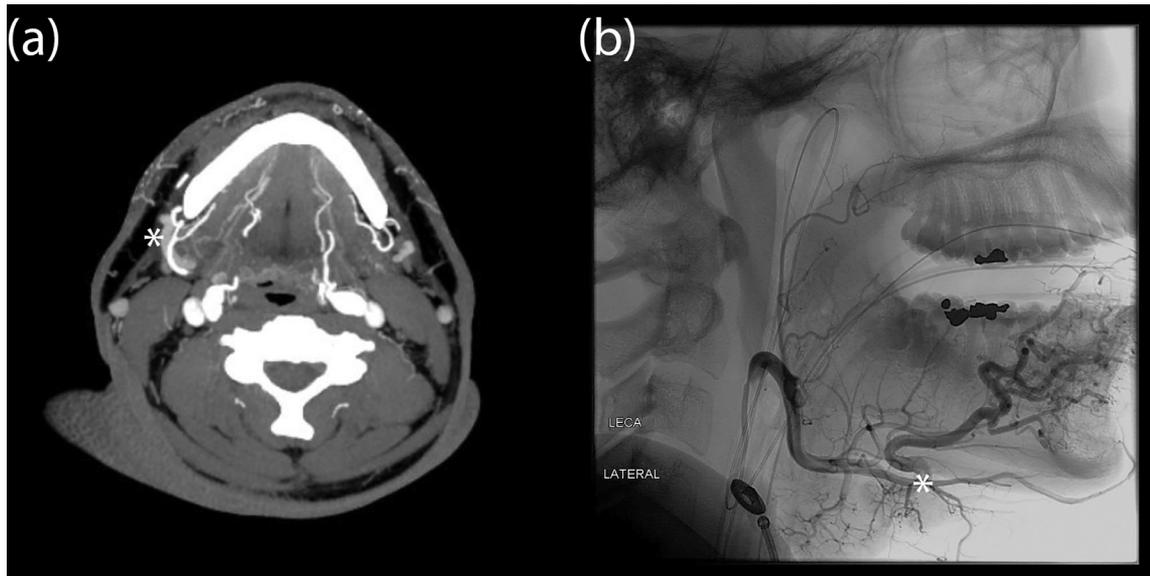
(A) Axial view of a CT angiogram and (B) sagittal view of an angiogram demonstrating course of the submental artery. *Indicates Submental artery branching point from the facial artery.
